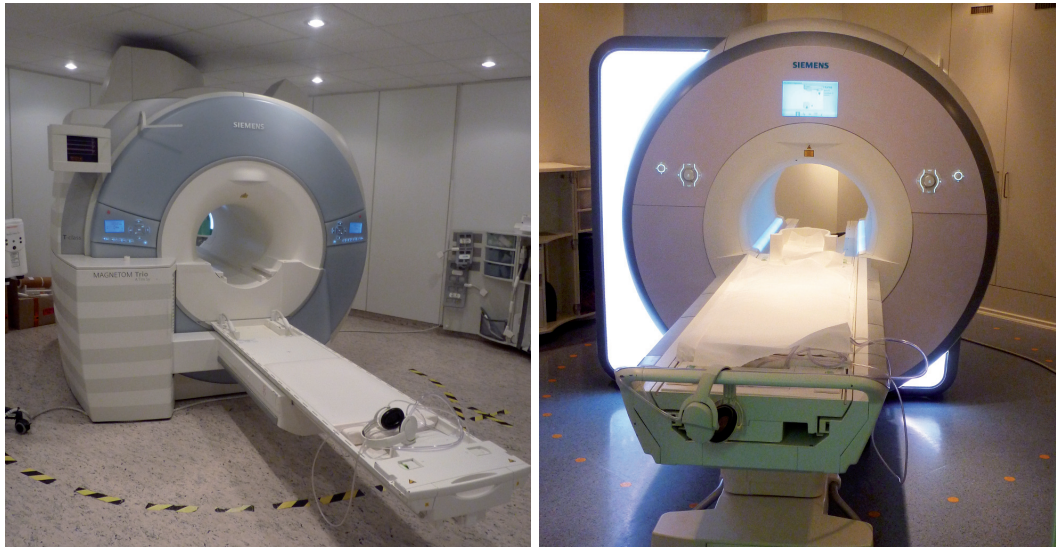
The MR tomographs Magnetom Trio (left) and Skyra (right) used for all MRI experiments in this work.*
